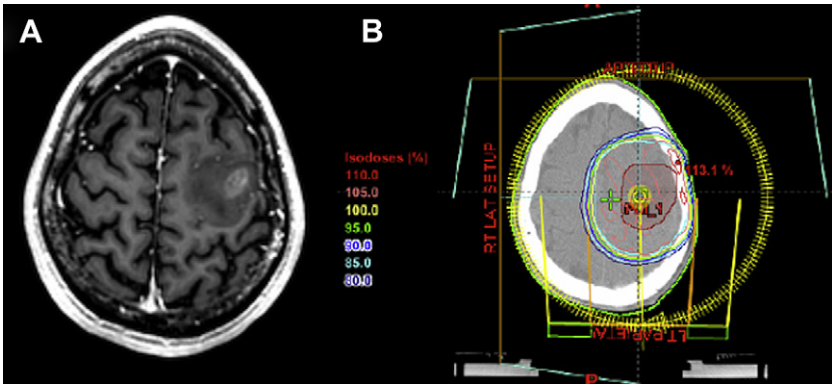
(A) A preoperative axial T1-weighted magnetic resonance sequence after gadolinium administration in a patient with a left frontal glioblastoma. (B) The postoperative conformal radiation delivery plan after gross total resection.
